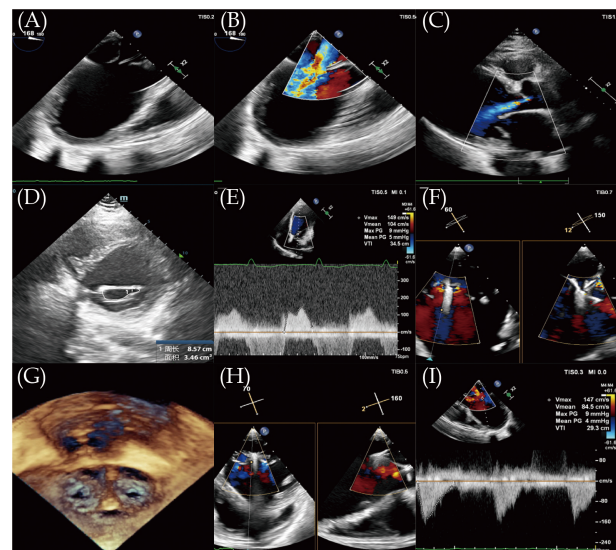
Echocardiographic images. Perioperative (A–E), intraoperative (F) and postoperative (G–I) echocardiographic images. (A): Thickened mitral valve leaflets with posterior leaflet tethering during systole; (B): severe mitral regurgitation; (C): dome shaped mitral valve in diastole, and thickened aortic valve leaflets with mild aortic regurgitation; (D): mitral valve area; (E): mean transmitral gradient; (F): TEER device positioning; (G): post-TEER 3D *en face* view; (H): post-TEER X-plane view showing mild mitral regurgitation; and (I): post-TEER mean transmitral gradient. TEER: transcatheter edge-to-edge repair.
